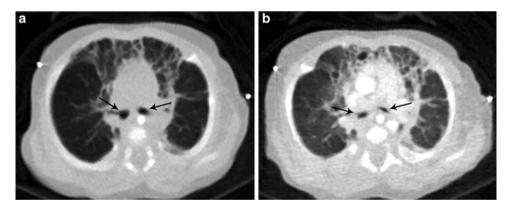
CT angiography demonstrating severe bronchomalacia. Significantly decreased size of bilateral bronchus during expiration (b) as compared to inhalation (a) in an infant with BPD
